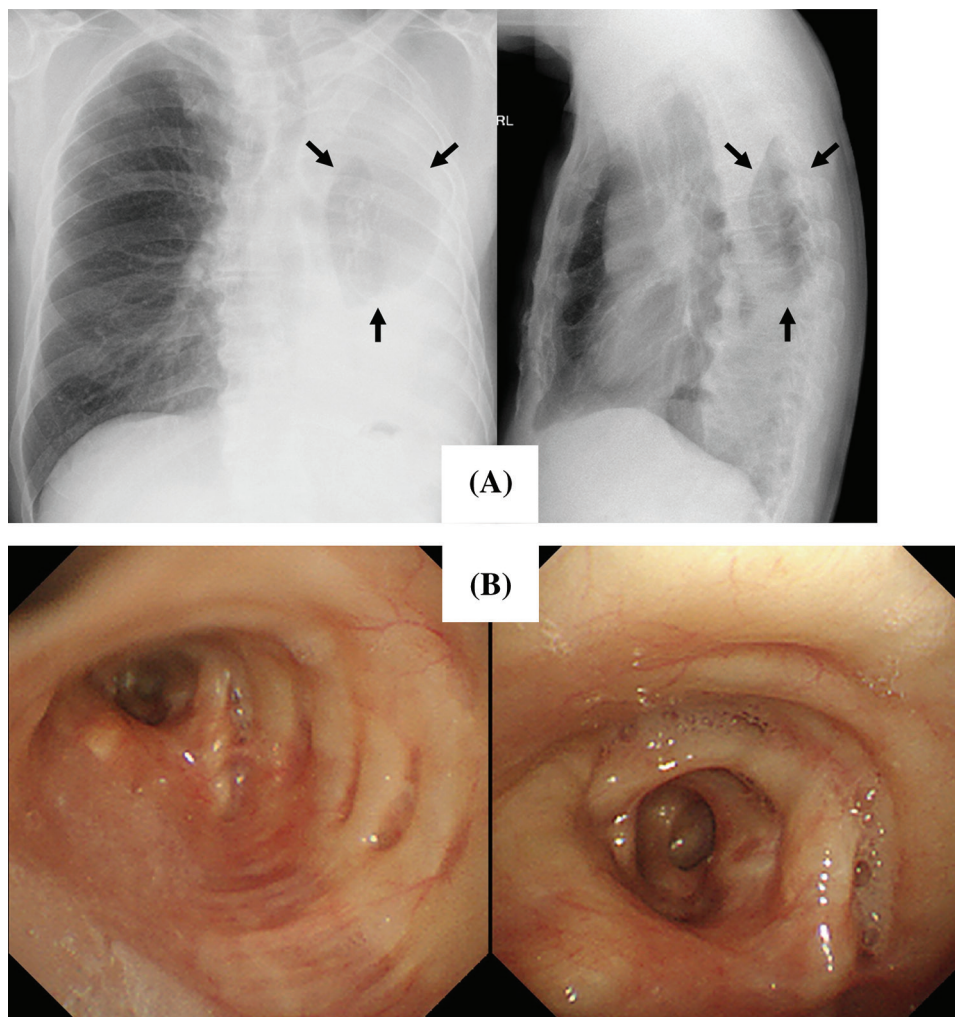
(A) Postoperative chest X-ray demonstrated that the superior segment was located at a suitable position and expanded properly. (B) Bronchoscopy showed patent anastomosis between the left main and the superior segmental bronchi.
